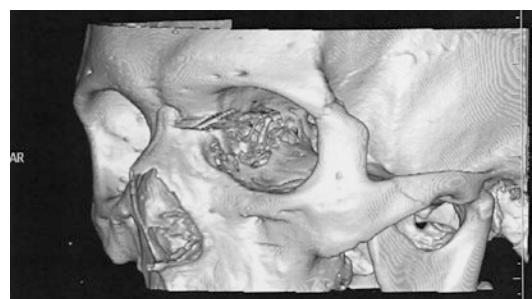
Three-dimensional reconstruction CT showed irregular metallic foreign body, on the medial margin of the left orbit (*left front view*)
